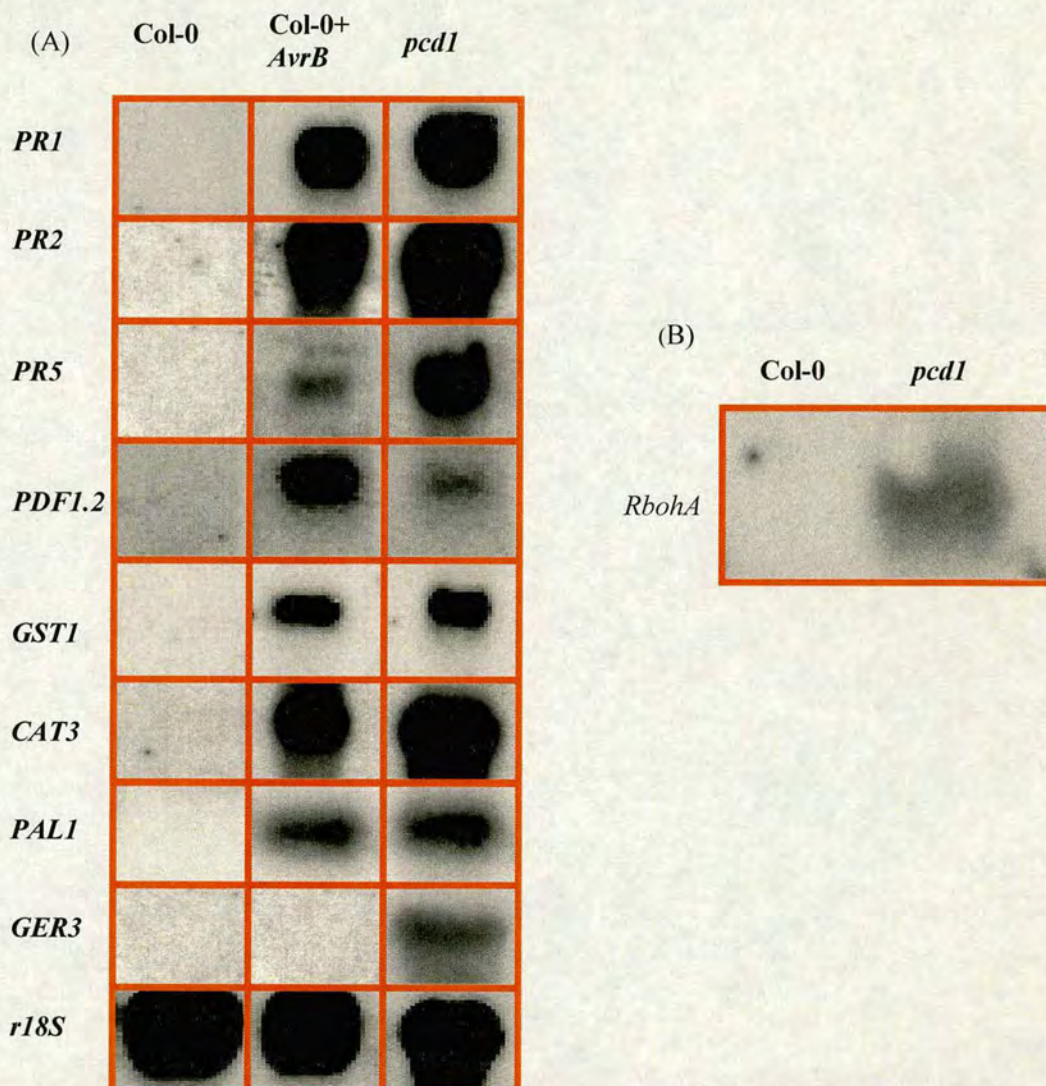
Northern analysis of *pcd1* plants. (A) Total RNA analysis in *pcd1*. ca. 10 μ g total RNA was used for each sample. As a positive control, wild-type Col-0 leaves were infiltrated with *Pst* DC3000 (*AvrB*) and leaf tissue samples were collected 24 hrs post-infiltration. In the case of *PAL1*, samples were collected 2 hrs post-infiltration. *r18S* was used as an RNA loading and transfer control. (B) Analysis of *RbohA* expression in *pcd1* plants. ca. 1 μ g of polyA-enriched RNA was loaded per each sample. All X-ray films were developed after exposure at -70°C for 24 hrs. Gene probes: *PR1,2&5*, pathogenesis-related 1,2&5; *PDF1.2*, plant defensin 1.2; *GST1*, glutathion S-transferase; *CAT3*, catalase 3; *PAL1*, phenylalanine-ammonia lyase 1; *GER3*, germin-like 3; *RbohA*, respiratory burst oxidase homologue A; *r18S*, ribosomal RNA gene encoding the 18S subunit.
